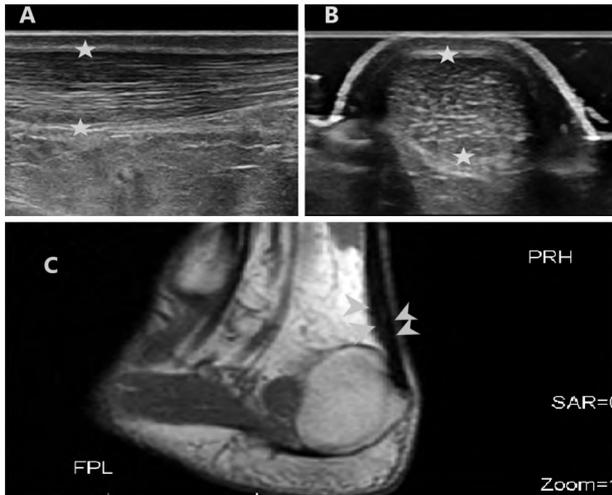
Longitudinal (A) and transverse (B) US images of a 30 years old male patient, runner, suffers from chronic ankle pain, showing thickened AT (stars) with hypo-echogenicity and preserved fibers (C) T1 weighted MRI image showing thickened distal portion of the AT (arrows) with no course interruption denoting AT Tendinosis.
